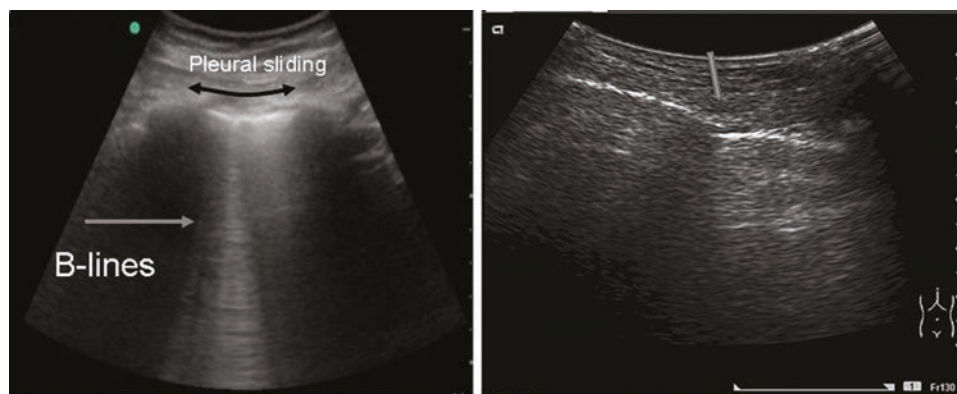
Ultrasound. (Left) No pneumothorax. (Right) Pneumothorax: absence of pleural sliding or B-lines.
